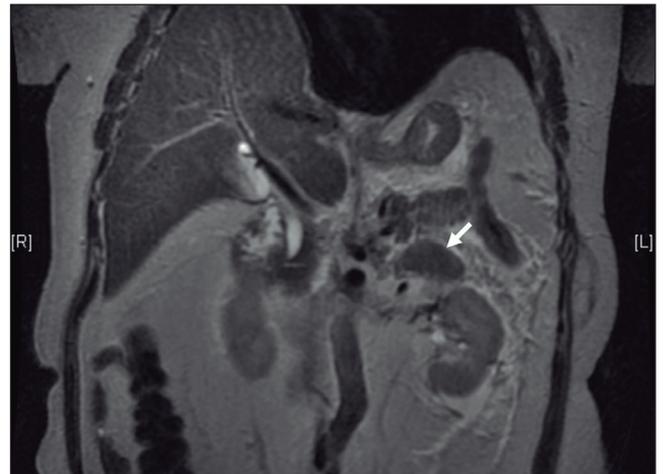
MRI T1 sequence. The remnant of the left adrenal gland is shown.
